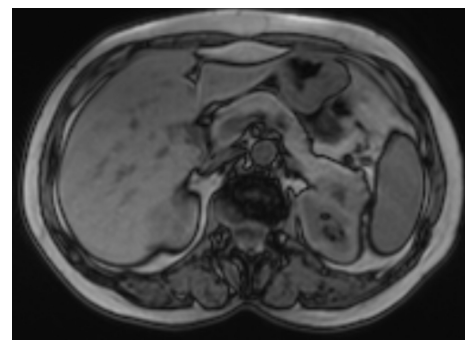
Out of phase (Contrast-enhanced abdominal magnetic resonance images of the patient)
